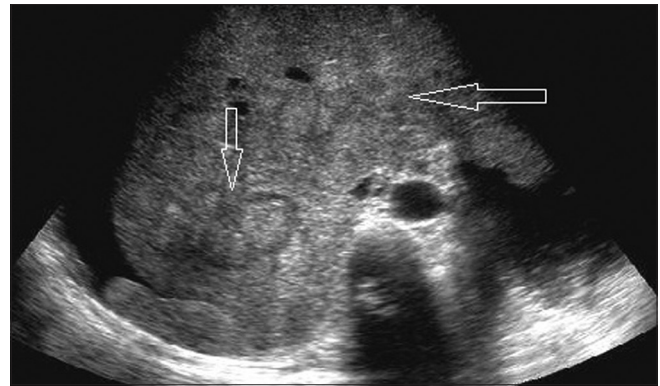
Ultrasonographic examination of the liver lesions
